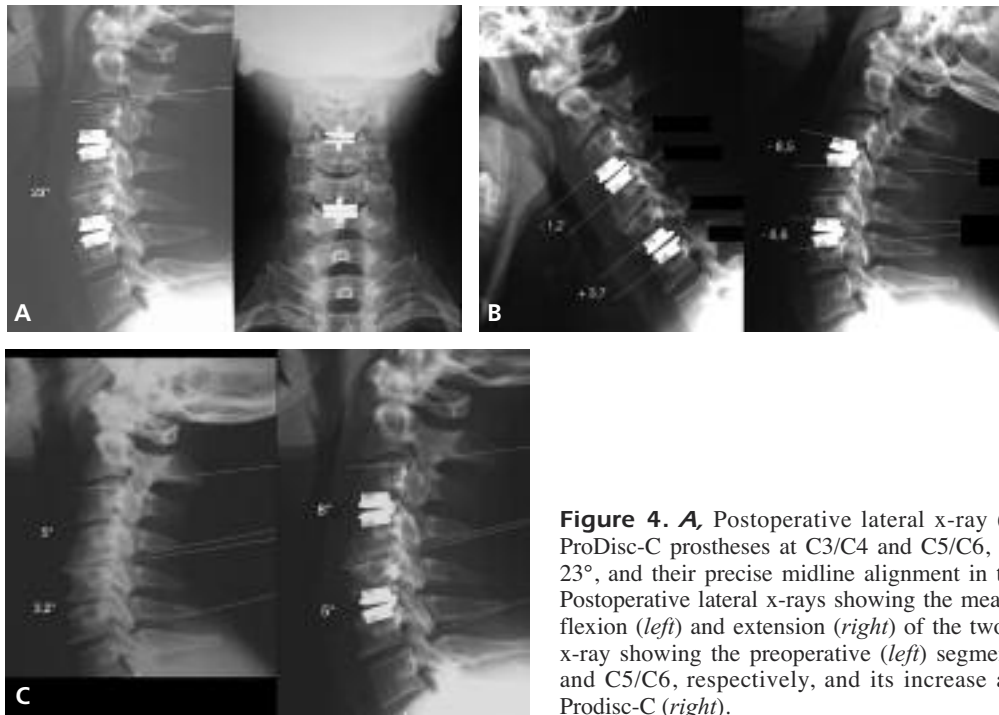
A, Postoperative lateral x-ray (*left*) showing the two ProDisc-C prostheses at C3/C4 and C5/C6, with a Cobb's angle of 23°, and their precise midline alignment in the AP view (*right*). B, Postoperative lateral x-rays showing the mean angular movement in flexion (*left*) and extension (*right*) of the two ProDisc-C. C, Lateral x-ray showing the preoperative (*left*) segmental kyphosis at C3/C4 and C5/C6, respectively, and its increase after arthroplasty with Prodisc-C (*right*).
